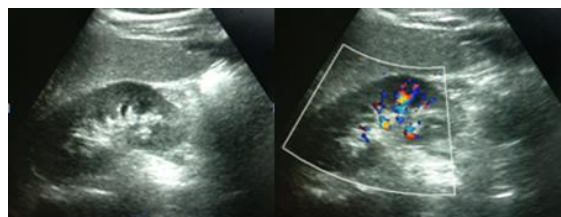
USG images of patient with segmental infarction of upper pole right kidney which shows normal USG but absence of vascularity in doppler.
